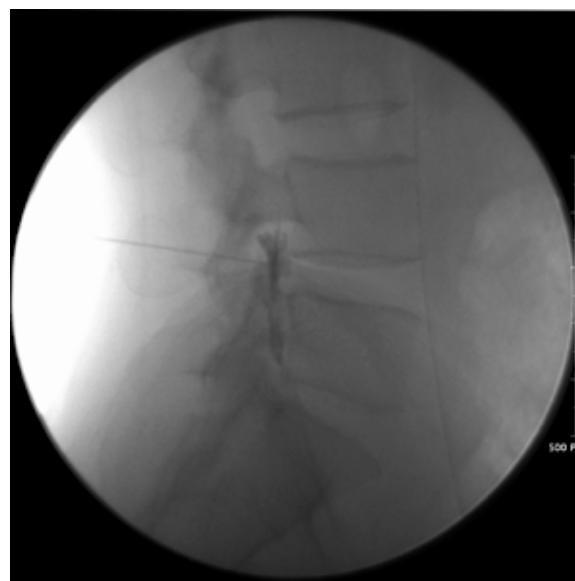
Classic transforaminal epidural steroid injection at L4-5. An oblique radiograph shows that contrast material has spread to L4-5 disc.
